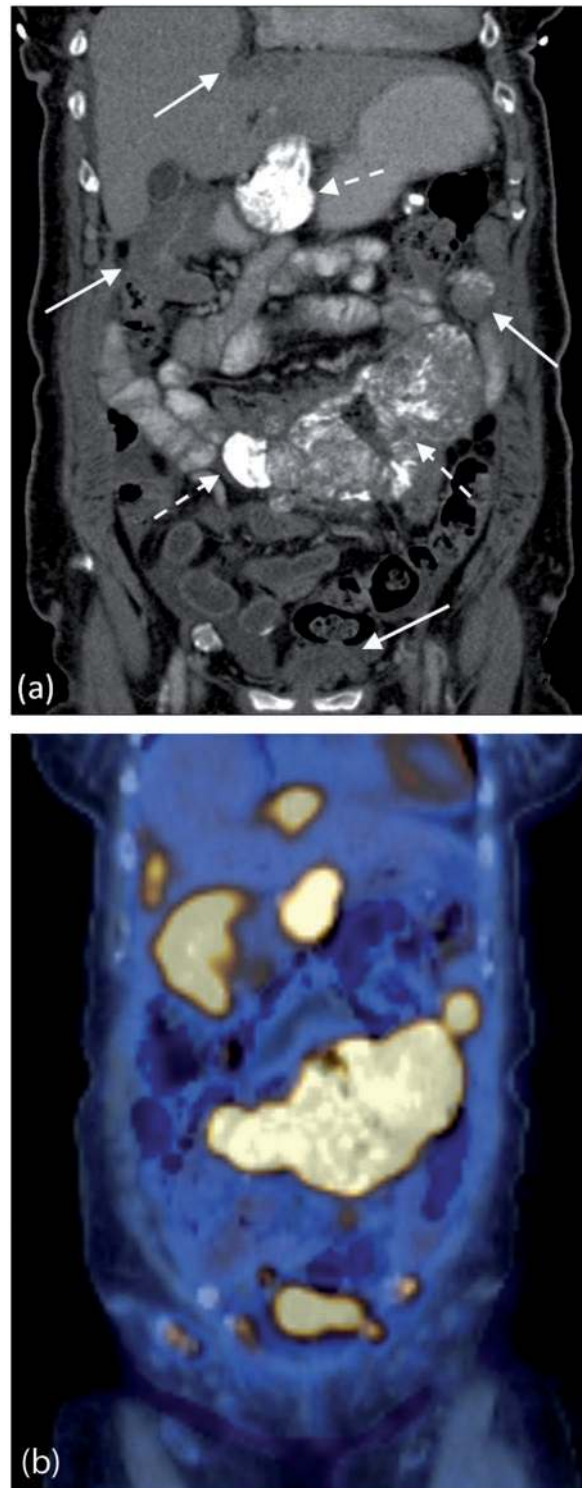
Metastatic ovarian carcinoma with calcified peritoneal deposits on FDG PET/CT. (a) Contrast-enhanced MDCT shows multiple calcified (dashed arrows) and non-calcified (solid arrows) peritoneal deposits. (b) Coronal fused PET/CT demonstrating avid FDG uptake within the calcified and non-calcified deposits.
